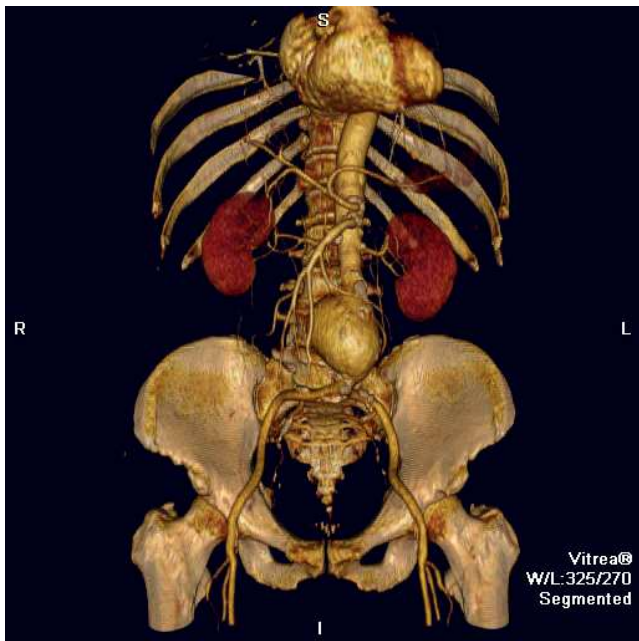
Visualization of a multi-slice thoracic and abdominal computed tomography revealing the presence of an abdominal aortic aneurysm.
